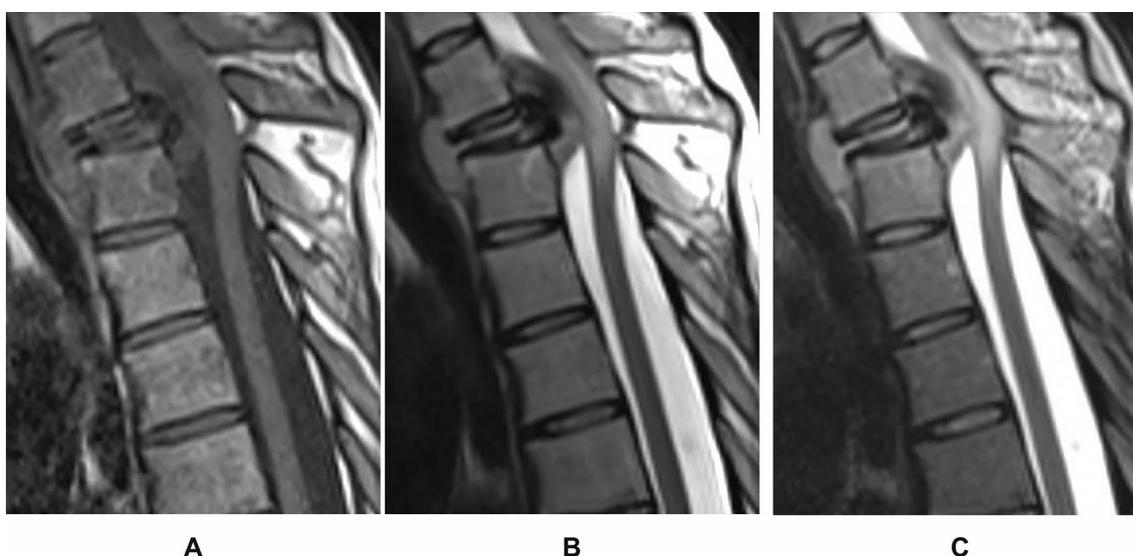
MRI of the cervical-thoracic junction 6 years before presentation: A – T1-weighted image; B – T2-weighted image; C – T2-weighted image Fat Suppression
